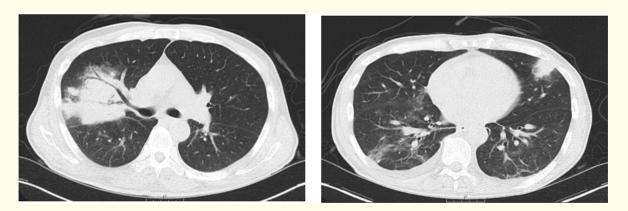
Computed tomography scan on admission showing mass-like consolidations in the right upper lobe (left panel) and lingula (right panel).
